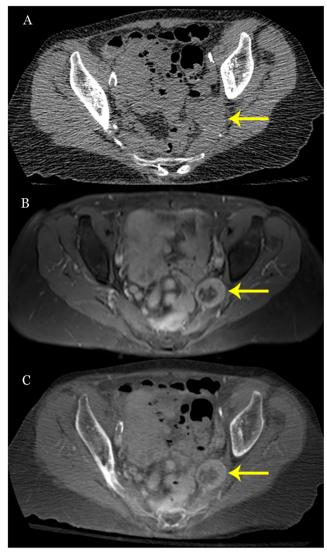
Fusion of different modalities Before/After: a contrast-enhanced T1-weighted fat-suppressed MRI where a nerve sheath tumor (*yellow arrows*) spanning the left sciatic nerve is well seen; b non-contrast CT scan where the bone is well seen, but the tumor is poorly differentiated from the surrounding soft tissue; c fused MRI and CT images performed in Mimics (as per Fig. 2) showing *both* the bony and soft tissue anatomy in exquisite detail, appearing as a contrast-enhanced CT scan
